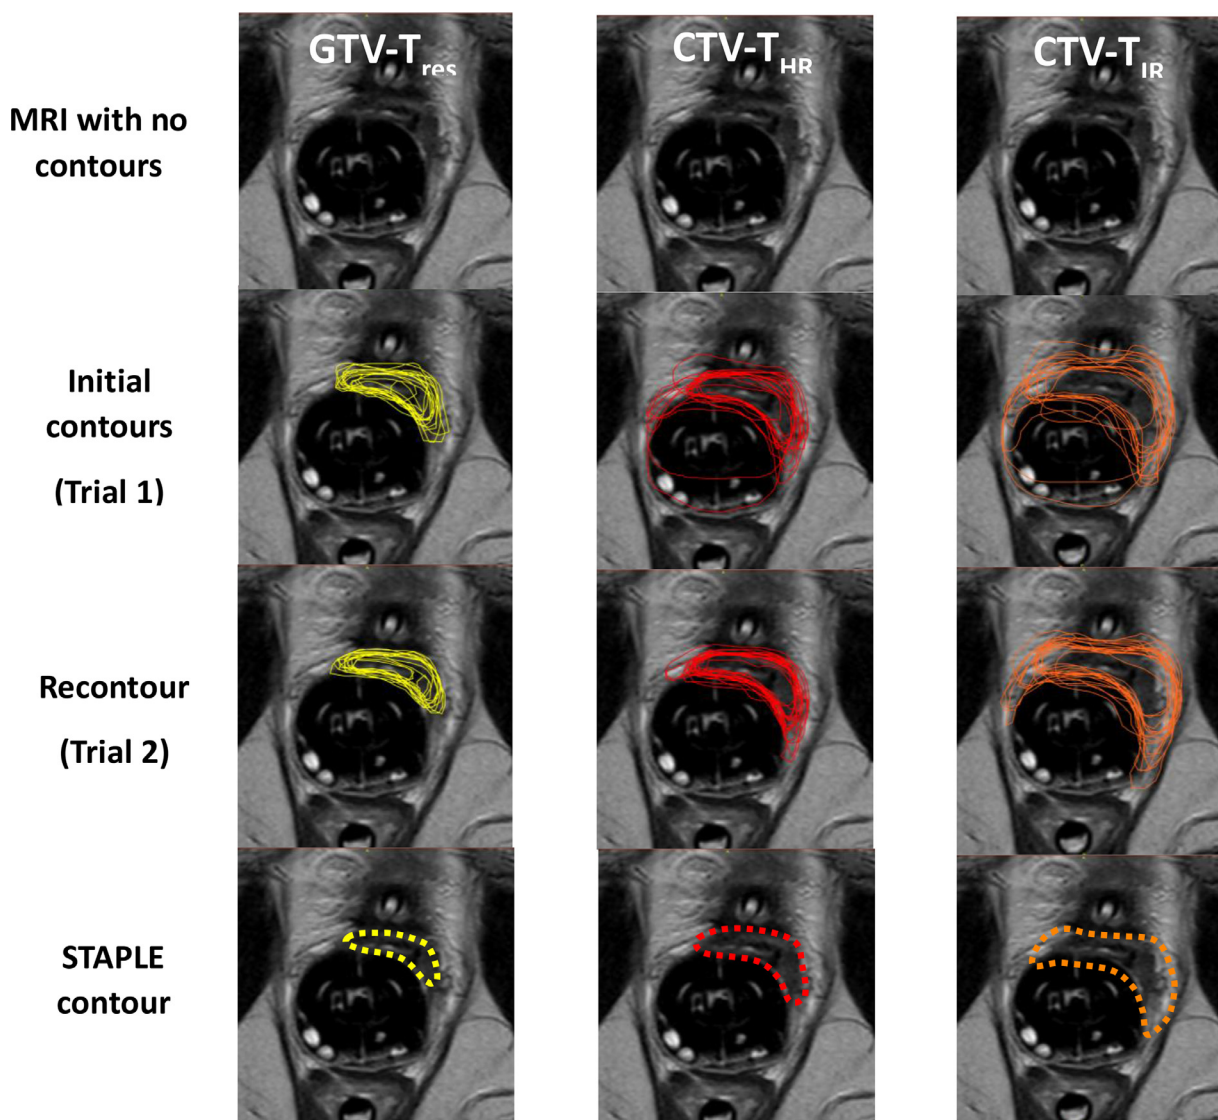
Example of development of consensus contours for GTV-T_{res}, CTV-T_{HR}, and CTV-T_{IR}. A representative axial slice is presented with no contours, initial contours (Trial 1), recontours (Trial 2), and STAPLE contour based on Trial 2 data. The case was a 54-year-old woman diagnosed with a FIGO IB1 cervical cancer treated definitively with surgery and no adjuvant treatment. She developed a biopsy proven vaginal recurrence 8 years later. On MRI she was noted to have a tumor at the vaginal apex. It measured 32 × 41 × 32 mm. She was treated with external beam radiation therapy with concurrent weekly cisplatin to 45 Gy. A repeat MRI, with an applicator in place for brachytherapy boost, showed a residual tumor measuring 14 × 16 × 14 mm.
